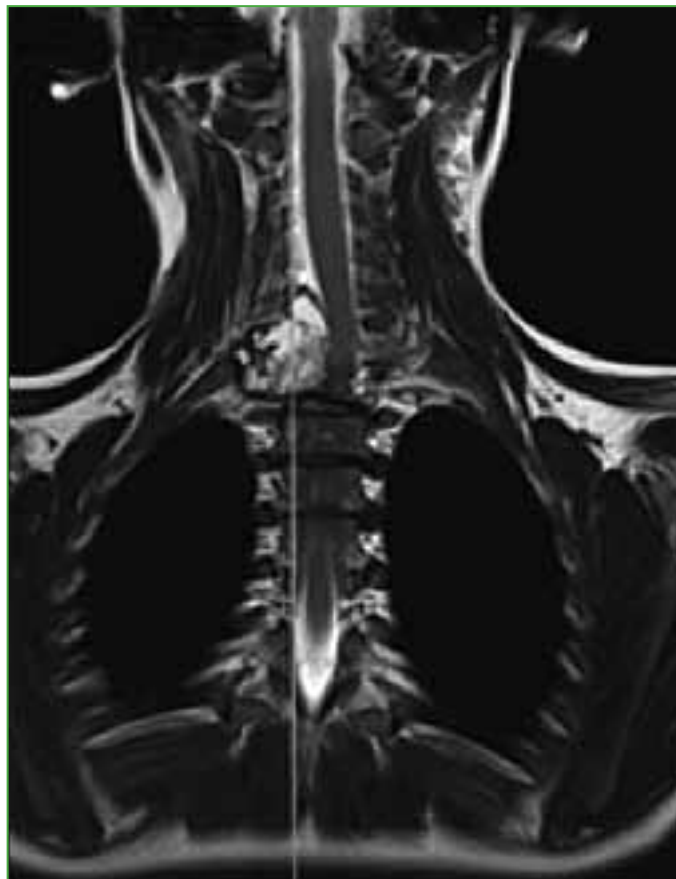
Coronal MRI of the cervical and proximal thoracic spine. An expansive cystic lesion with characteristic fluid–fluid levels is visualized.
